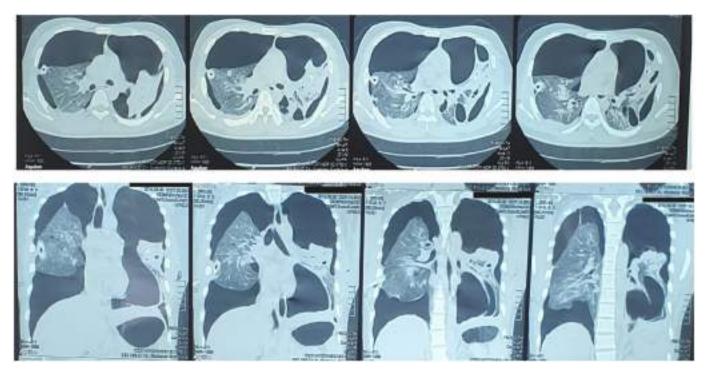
CT scan showing multiple blebs in the apical segment of the right superior lobe and the apicoposterior segment of the left superior lobe.
